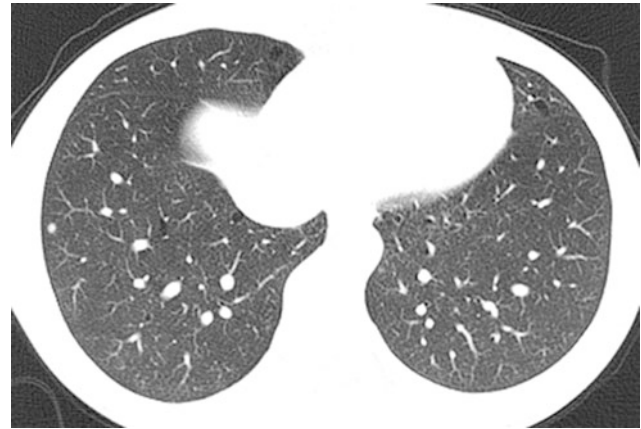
Tuberous sclerosis (TS). An axial chest CT image in a 17-year-old female with TS shows several, small, round cysts of the lung bases bilaterally, consistent with lymphangioleiomyomatosis. In addition, there is a small, well-defined nodule of the peripheral lateral right lower lobe, possibly related to micronodular pneumocyte hyperplasia that occurs in the setting of TS
